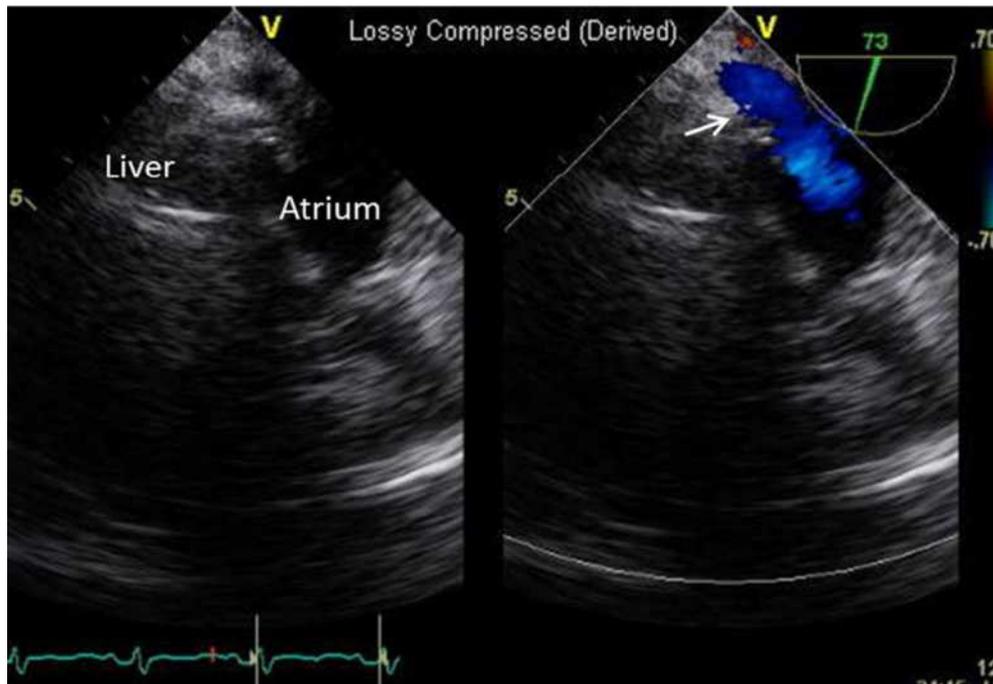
Transesophageal echocardiogram image showing residual venous drainage directly to the atrium (arrow) inferiorly; this drainage is separate from where the pulmonary veins drain.
